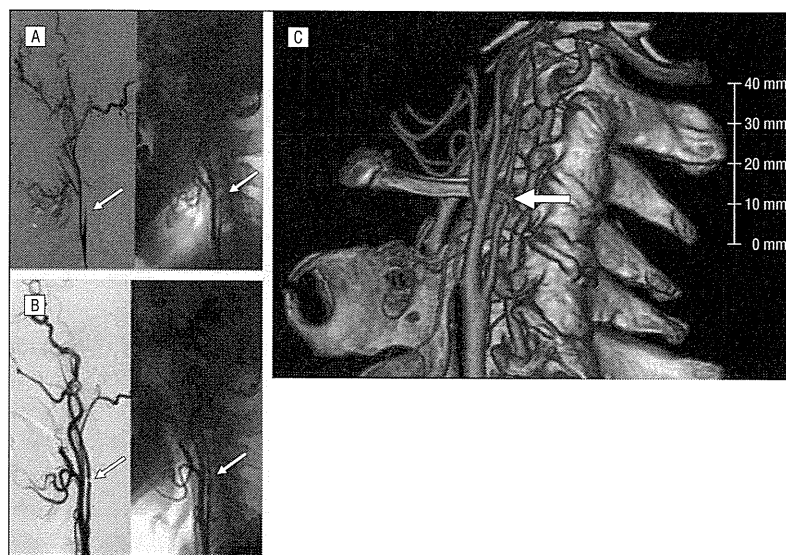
Imaging findings of the left internal carotid artery and hyoid bone. Cerebral angiography showed occlusion of the internal carotid artery 1 year before admission (A), recanalized, with severe segmental stenosis on day 13 (B). C, Helical computed tomography shows the greater horn of hyoid bone compressing the narrowest segment of the left internal carotid artery from behind.
